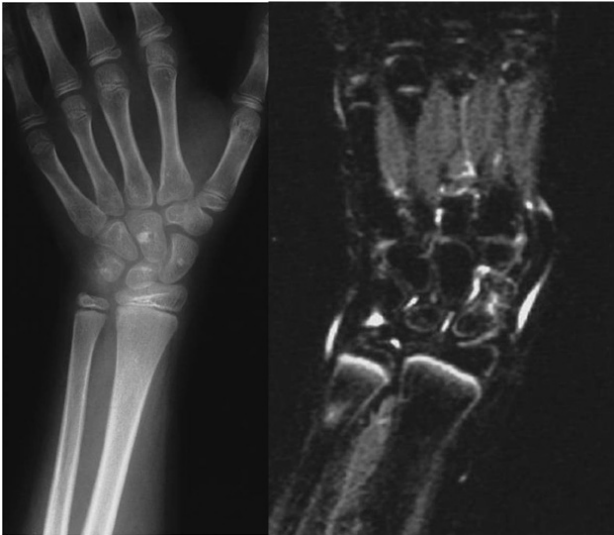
An 8-year-old girl with a radiographically occult scaphoid injury that was immobilized in plaster. A MRI was performed due to residual symptoms, following cast removal, 5 weeks post-injury. Short tau inversion recovery image showed bone bruising of the mid-portion of the scaphoid and fluid signal around most of the carpal bones. Two bone islands on the scaphoid and the capitate were found incidentally on the radiographs.
